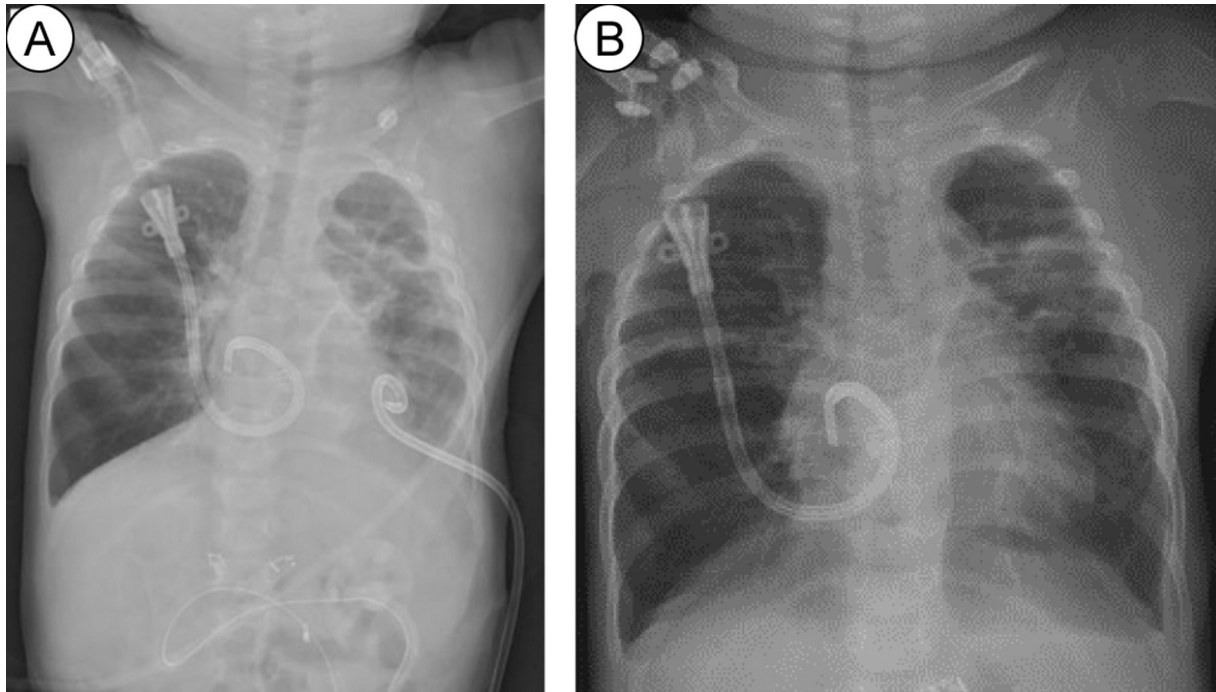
After removal of permanent catheter inserted on left jugular vein, patients undergoing hemodialysis using catheter inserted directly to the right atrium. (A) For chest X-ray, day before surgery, pigtail was inserted on left-sided lung. (B) At postoperative 10 weeks, chest X-ray shows no aggravation of effusion, even after pigtail on left lung was removed.
